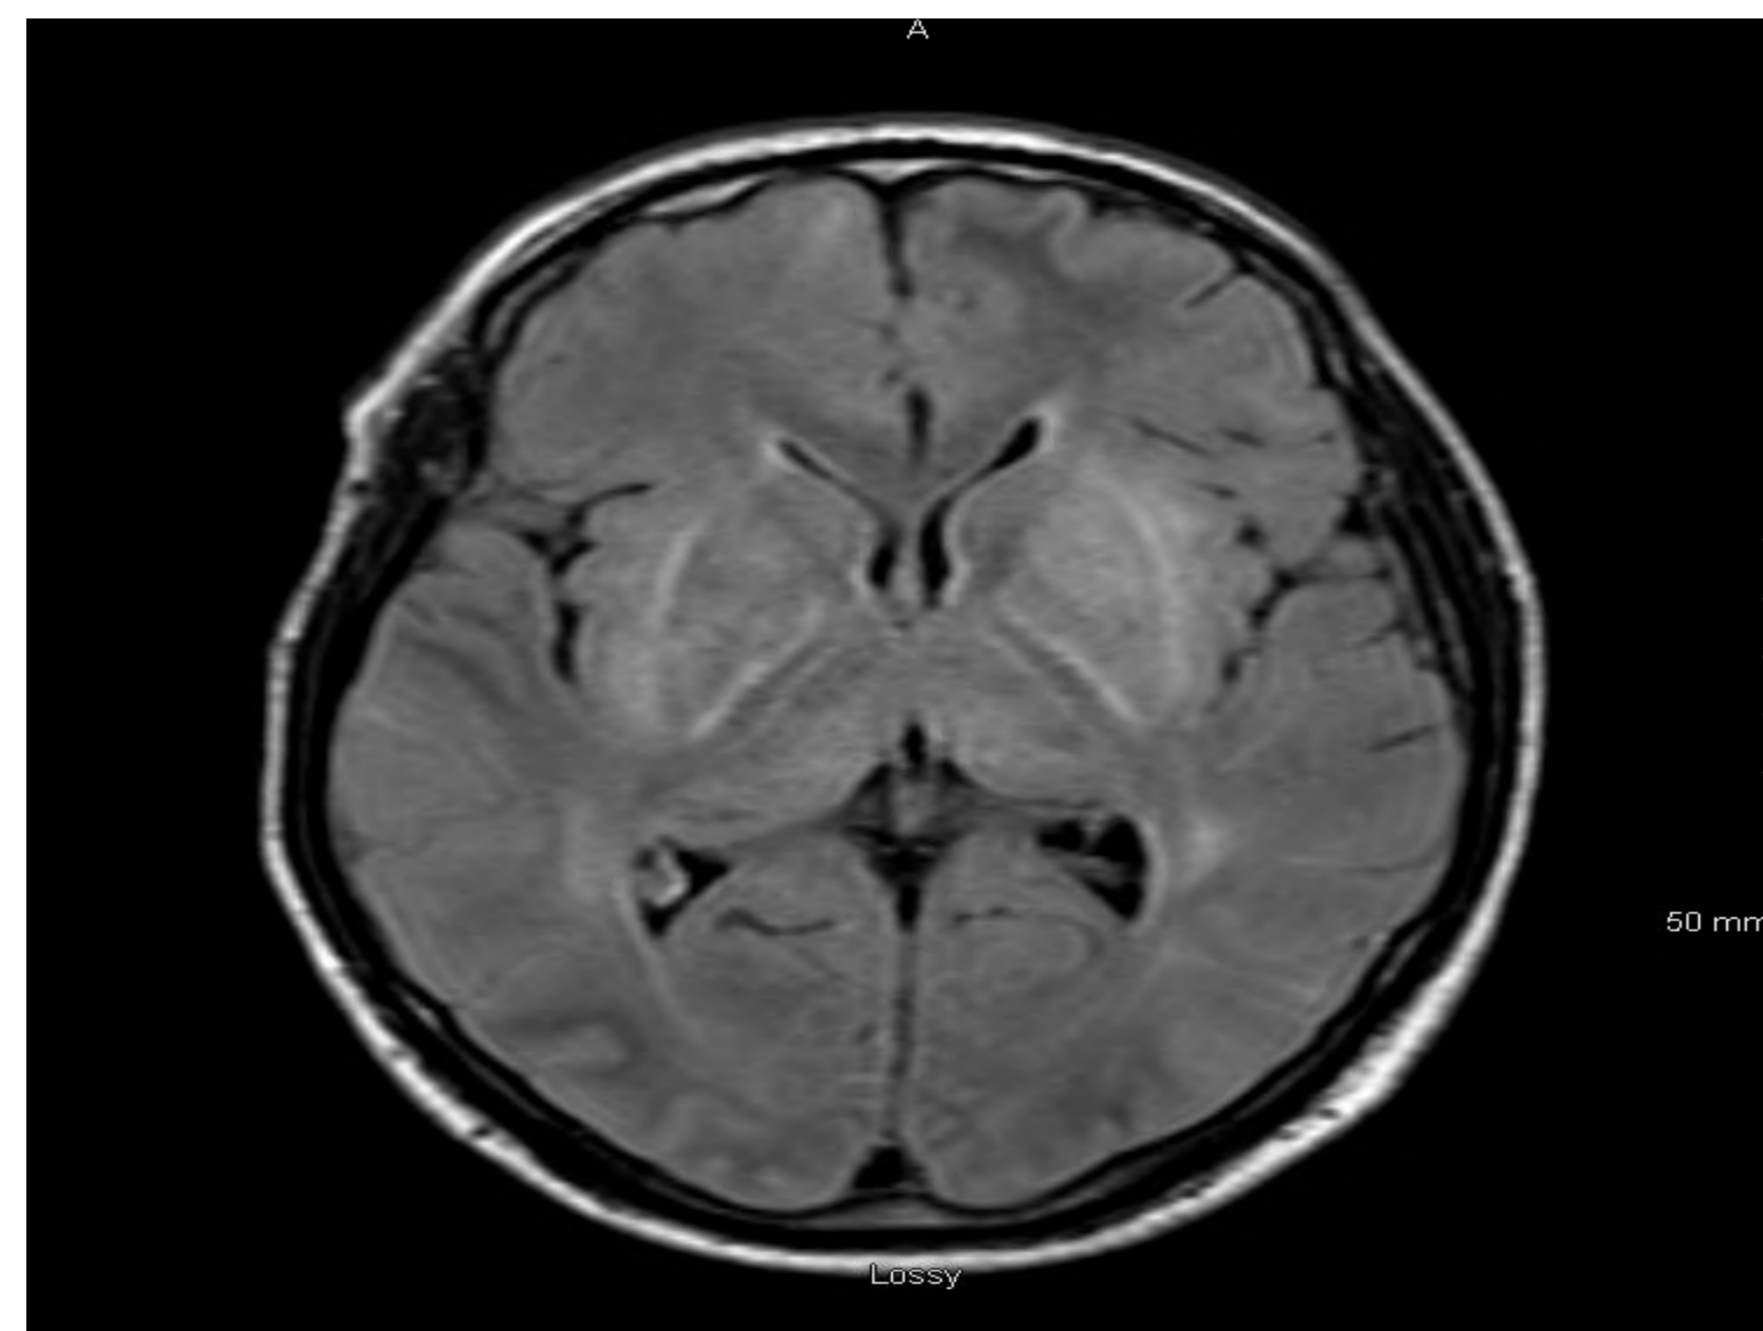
MRI showing signal change at the basal ganglia
